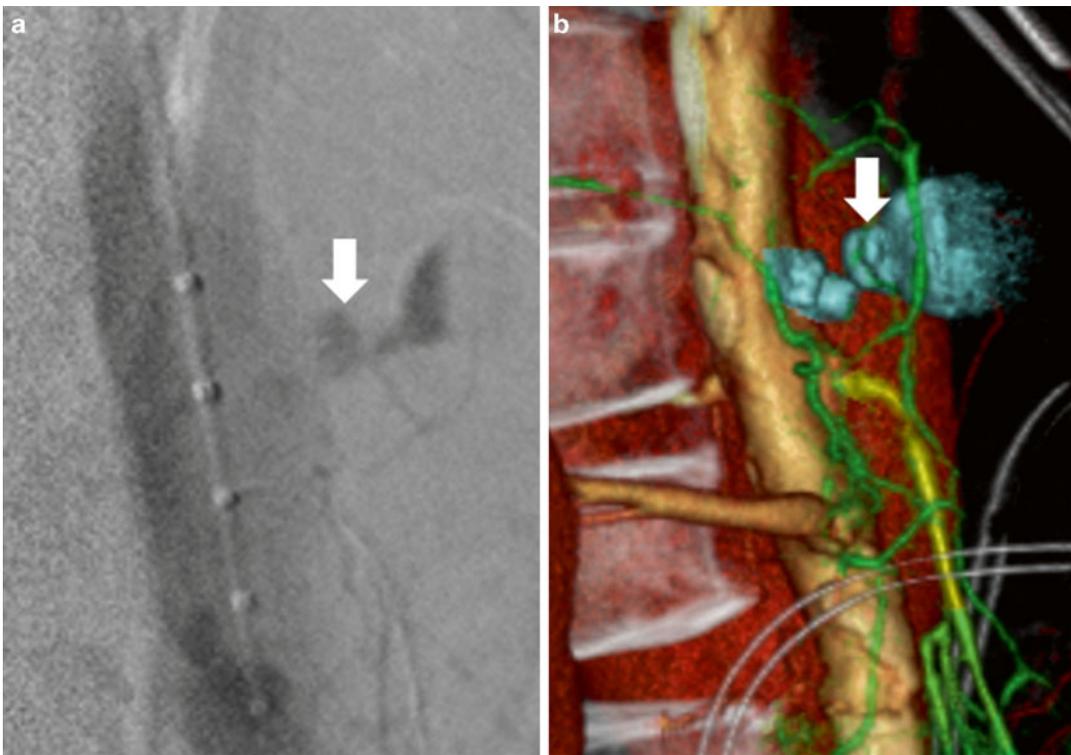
A sagittal image of angiography (a) and three-dimensional computed tomography (b) show the extravasation (arrows) from a pseudoaneurysm in the celiac trunk
